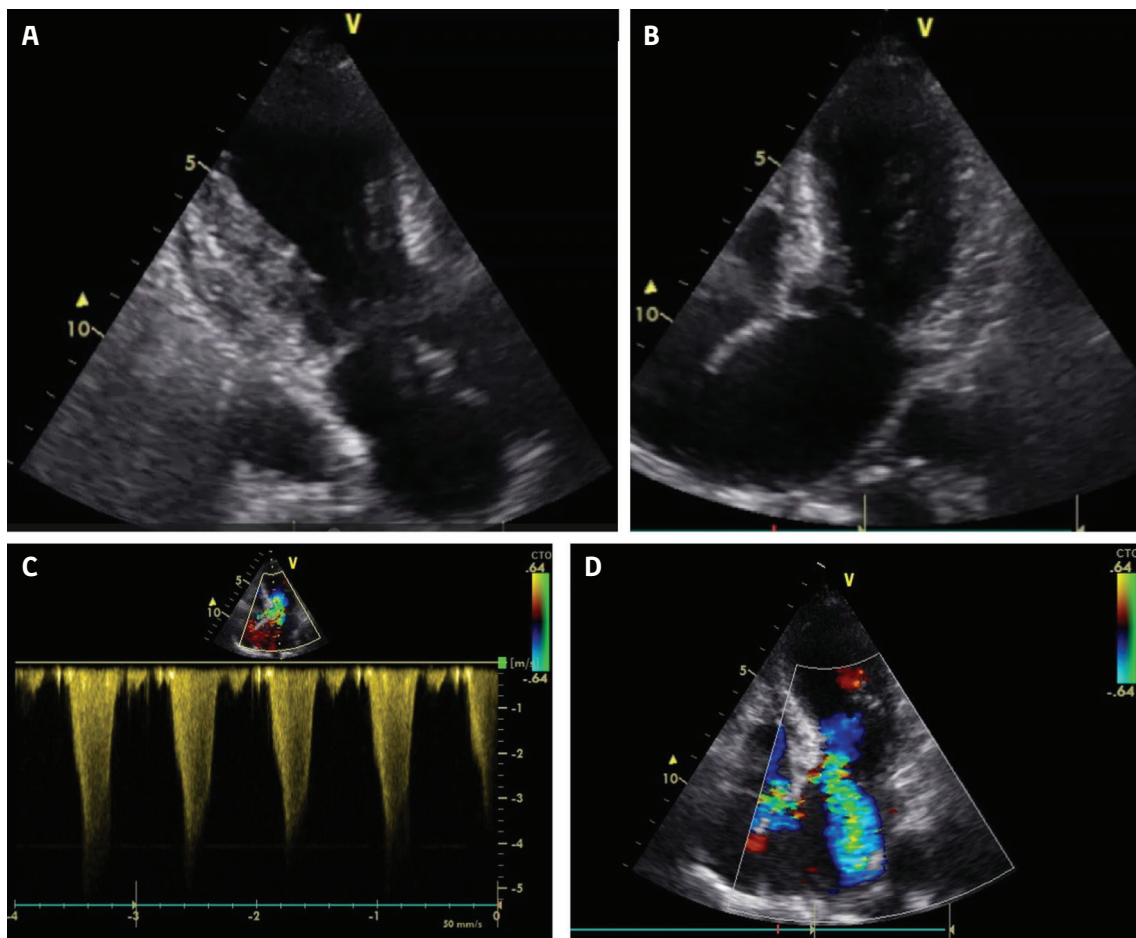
Two-dimensional echocardiography at presentation. Observe the clear left ventricular outflow tract obstruction with an approximately 75 mmHg gradient (A-C) and severe mitral insufficiency (D).
